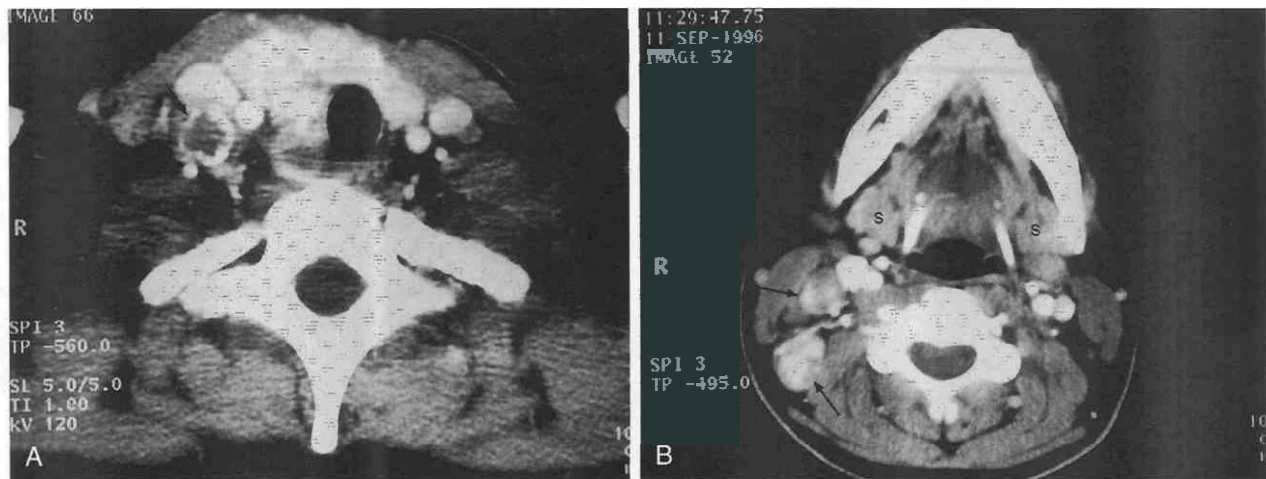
Papillary carcinoma with nodal metastases. *A*, Axial postcontrast CT shows a heterogeneous, multilobular mass involving the right thyroid lobe without tracheal invasion. A peripherally calcified lymph node (*arrow*) is seen in the right tracheoesophageal groove. *B*, CT in the same patient at the level of the mandible shows two enlarged, enhancing lymph nodes (*arrows*) within the right posterior triangle and one along the left jugular chain. Normal submandibular glands (*s*).
